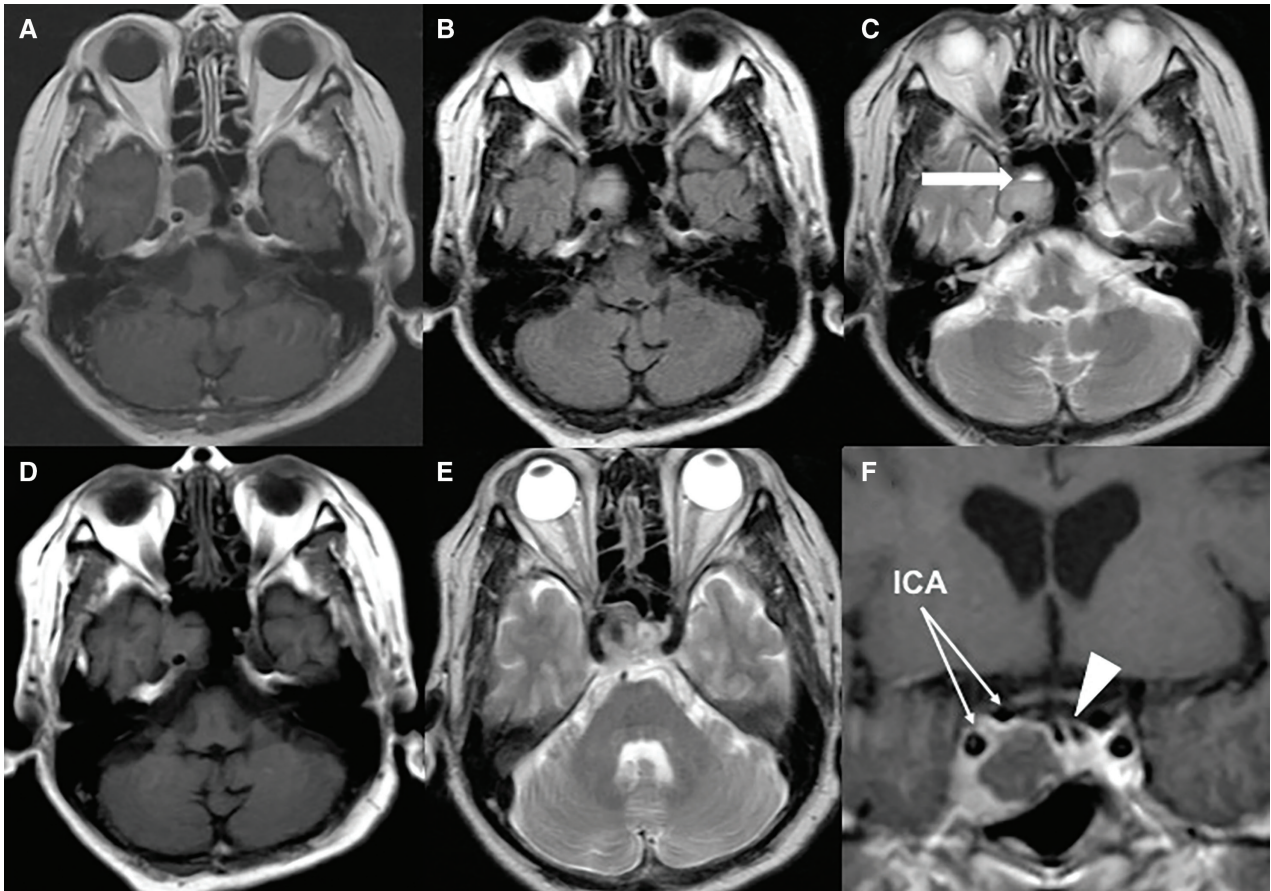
MRI findings at the time of admission. T1-weighted sequence with gadolinium enhancement reveals a cystic mass in the right cavernous sinus (A). Fluid-attenuated inversion recovery (B), T2-weighted image (C), and T1-weighted image (D). T2-weighted image (C) shows the fluid–fluid level (arrow), and T2-weighted image (E) sequence reveals a lesion with a high-signal intensity in the left cavernous sinus. The prolactinoma is adjacent to the right cavernous sinus portion of the ICA on the T1-weighted sequence with gadolinium enhancement (F). The pituitary stalk is displaced by the compression of tumor (arrowhead). MRI: magnetic resonance imaging, ICA: internal carotid artery.
